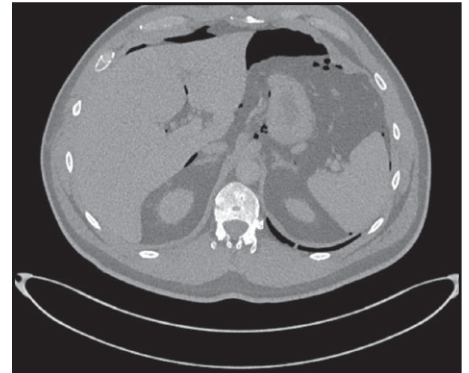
Pneumoperitoneum noted on diagnostic abdominal computed tomography (CT)
